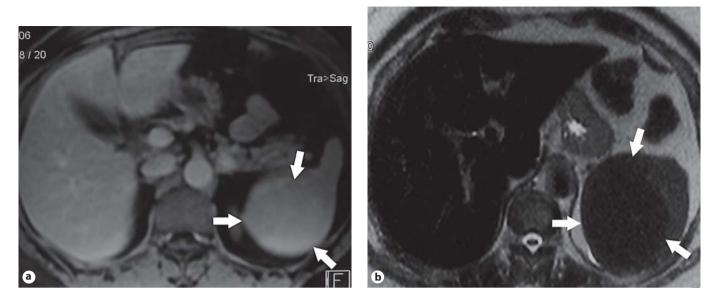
Axial MR images show a $5 \times 5 \times 4$ cm well-defined solid mass. a Gadolinium-enhanced MR images demonstrate a well-defined, uniformly enhanced lesion (arrows) originating from the medial aspect of the spleen during the hepatic venous phase. b Axial T2-weighted HASTE image following the administration of ferumoxide contrast agent demonstrates a splenic lesion (arrows) with a decreased signal intensity.
